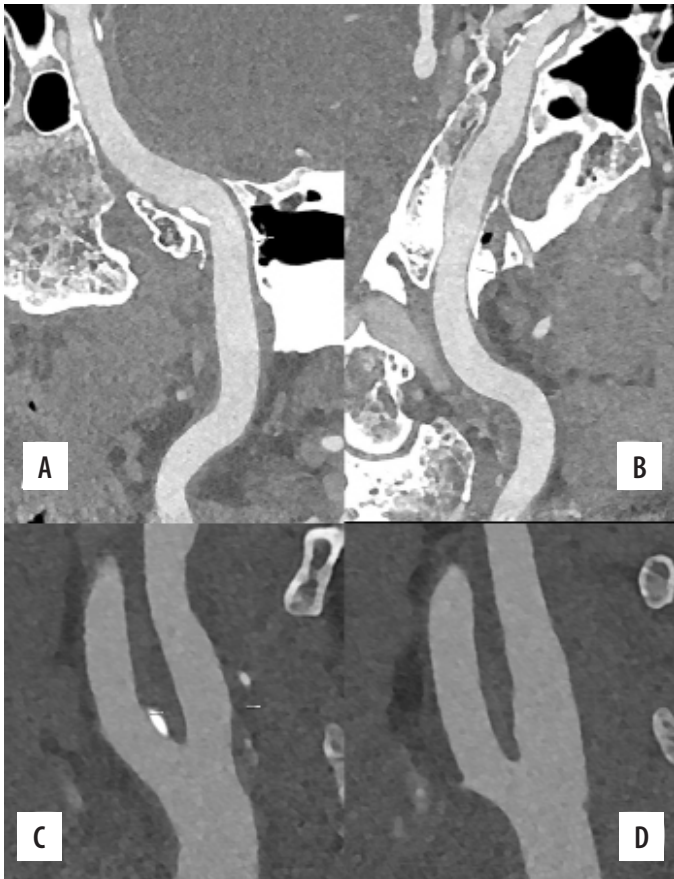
Photon-counting computed tomography (PCCT) angiography example of the intra-cranial arteries and carotid arteries with mild atherosclerosis. The figure shows the intrapetrous internal carotid arteries (A, B) with a curved multiplanar reconstruction along the central lumen line; the bilateral bifurcation of the carotid arteries is displayed in C (right) and D (left). The scan was performed on a commercial whole-body dual-source photon-counting CT scanner (Naeotom Alpha, Siemens Healthineers, Forchheim, Germany) with 0.2 mm slice thickness, 0.1 mm reconstruction increment, and FOV 140 mm. The images are displayed with a resolution matrix of 1024 × 1024 pixels on the source axial reconstructions with a kernel filtering of Bv60 (vascular kernel medium-sharp) and with the maximum intensity of Quantum Iterative Reconstruction (QIR 4). The actual displayed resolution is 0.1 mm (100 microns)
